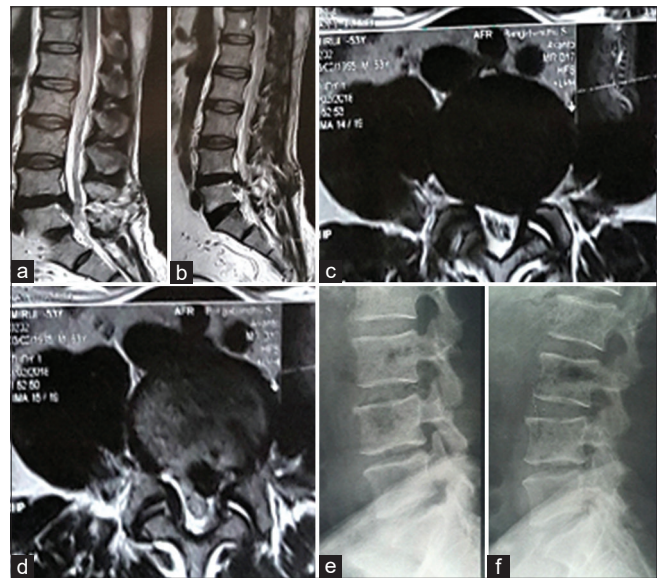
Revision discectomy is done of the same patient on February 20, 2018 after 4 years. (a-d) shows recurrence disc herniation in sagittal and axial magnetic resonance imaging in T2W image, (e) and (f) preoperative dynamic X-ray in lateral position showing no instability.
